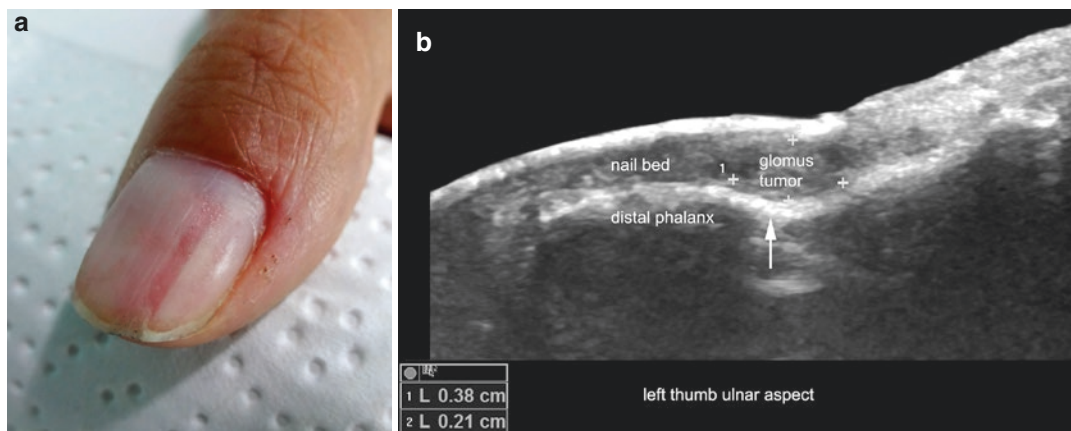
Glomus tumor (proximal location). (a) Clinical image shows longitudinal erythronychia in the left thumb. (b–d) Greyscale ultrasound images (b, longitudinal; c, transverse; d, longitudinal comparison between radial and ulnar aspect) show 3.8-mm (longitudinal) \times 2.1-mm (thickness) \times 3.7-mm (transverse) well-defined
